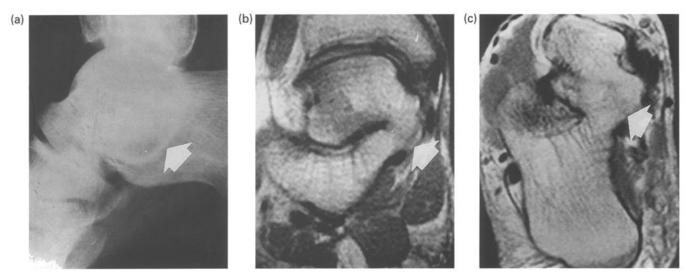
Talocalcaneal coalition (white arrows): plain film (a) shows the "C sign." On coronal (b) and transverse scans, the complete osseous talocalcaneal coalition is well defined.
